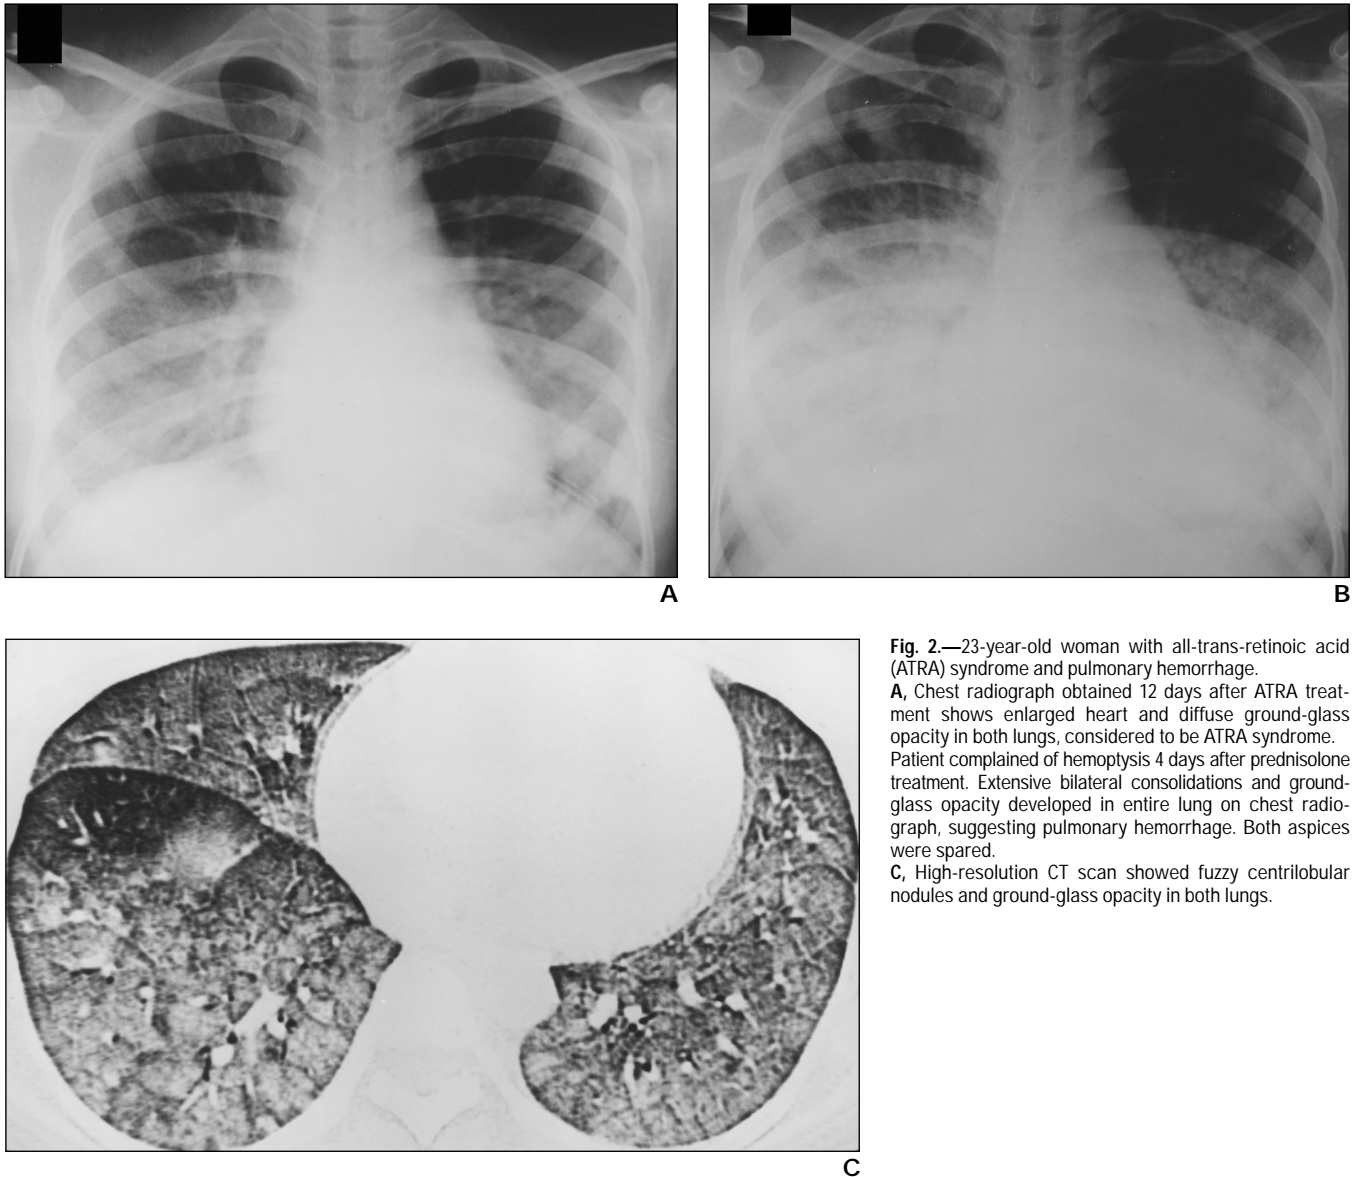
23-year-old woman with all-trans-retinoic acid (ATRA) syndrome and pulmonary hemorrhage. A, Chest radiograph obtained 12 days after ATRA treatment shows enlarged heart and diffuse ground-glass opacity in both lungs, considered to be ATRA syndrome. Patient complained of hemoptysis 4 days after prednisolone treatment. Extensive bilateral consolidations and ground-glass opacity developed in entire lung on chest radiograph, suggesting pulmonary hemorrhage. Both apices were spared. C, High-resolution CT scan showed fuzzy centrilobular nodules and ground-glass opacity in both lungs.
